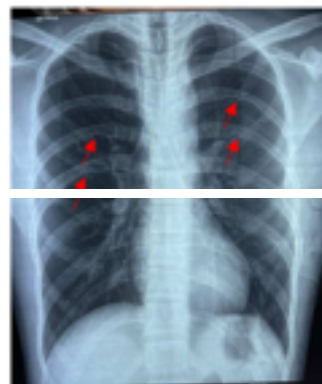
Front thoracic X-ray of CASE N°1 showing rib erosions in the form of an irregular appearance of the inferior cortex of certain ribs: Rib-notching (arrows).
